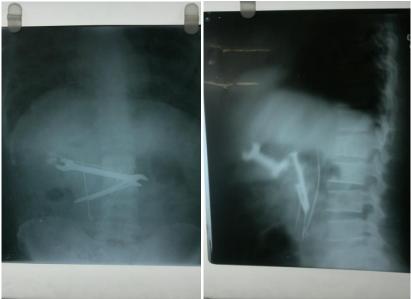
Plain abdominal radiograph with radio-opaque shadows.
